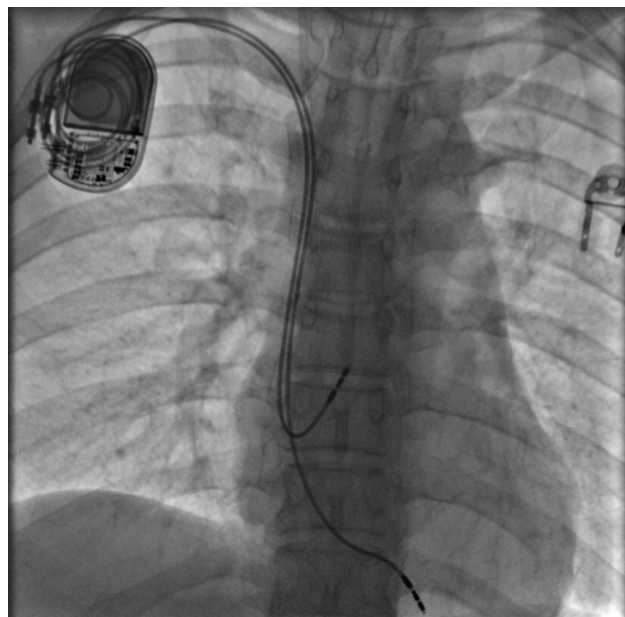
X-ray after new pacing system implantation.
